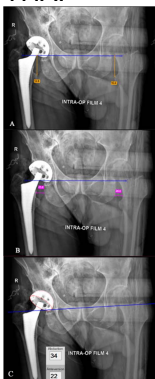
Trial radiographs demonstrating how image analysis software measures limb length (A), femoral offset (B), and cup abduction and anteversion angles (C) using digital radiography.
